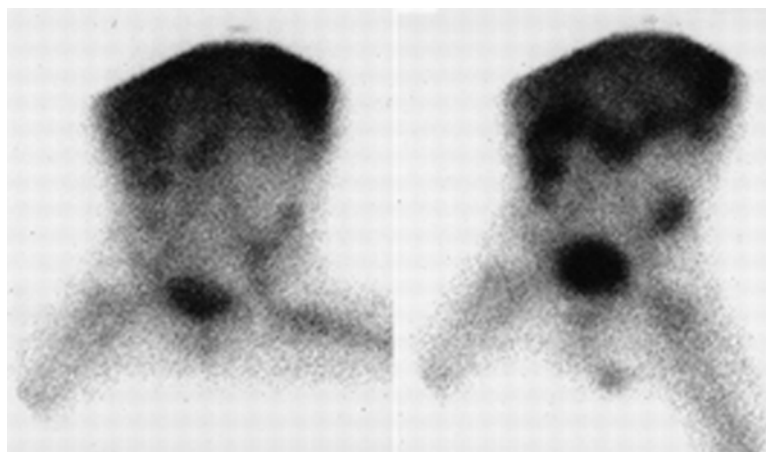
Massive lower gastrointestinal bleeding. Technetium-99m-RBC scintigraphy from an 18-month-old boy with acute leukemia on treatment presenting with a falling hematocrit and increasingly severe gastrointestinal bleeding. The sequential anterior images reveal abnormal tracer accumulation first at the level of the epigastrium
